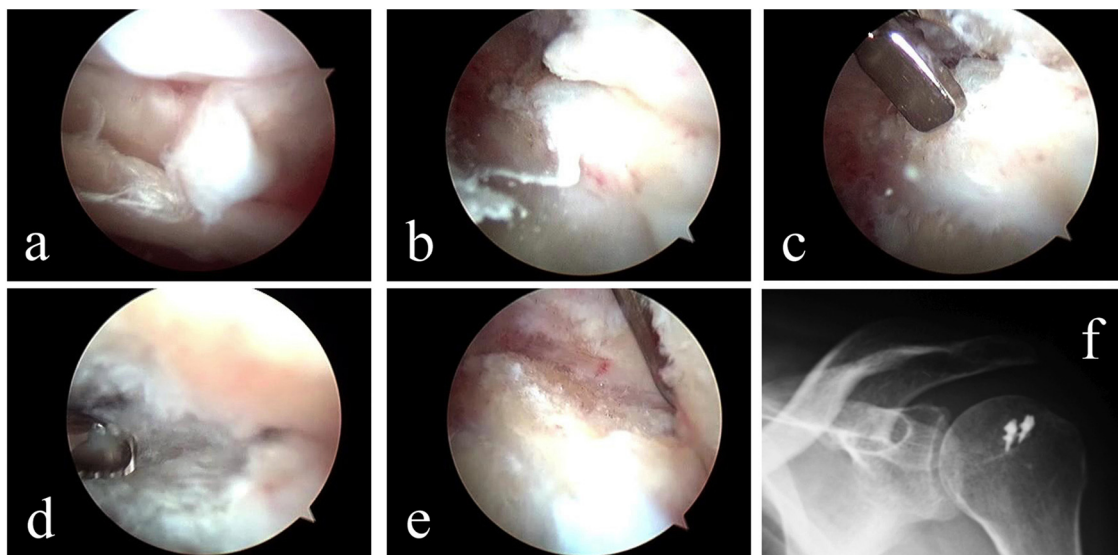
(a) Arthroscopic image of the bursal side of the supraspinatus muscle: with the aid of a tracer, introduced from the posterior access port with a lateral optical port, the intramuscular space that contains the calcium deposit is detected after performing an accurate bursectomy using a motorized shaver. In this picture, the calcium deposit is visible below the tip of the tracer. (b) Intramuscular arthroscopic image: the calcium deposit can be identified. (c) Intramuscular arthroscopic image: procedure for the removal of the calcium deposit using motorized drill. (d) X-ray of calcification at the biceps anchor. (e, f) MRI pictures of calcification in the bicipital anchor.
